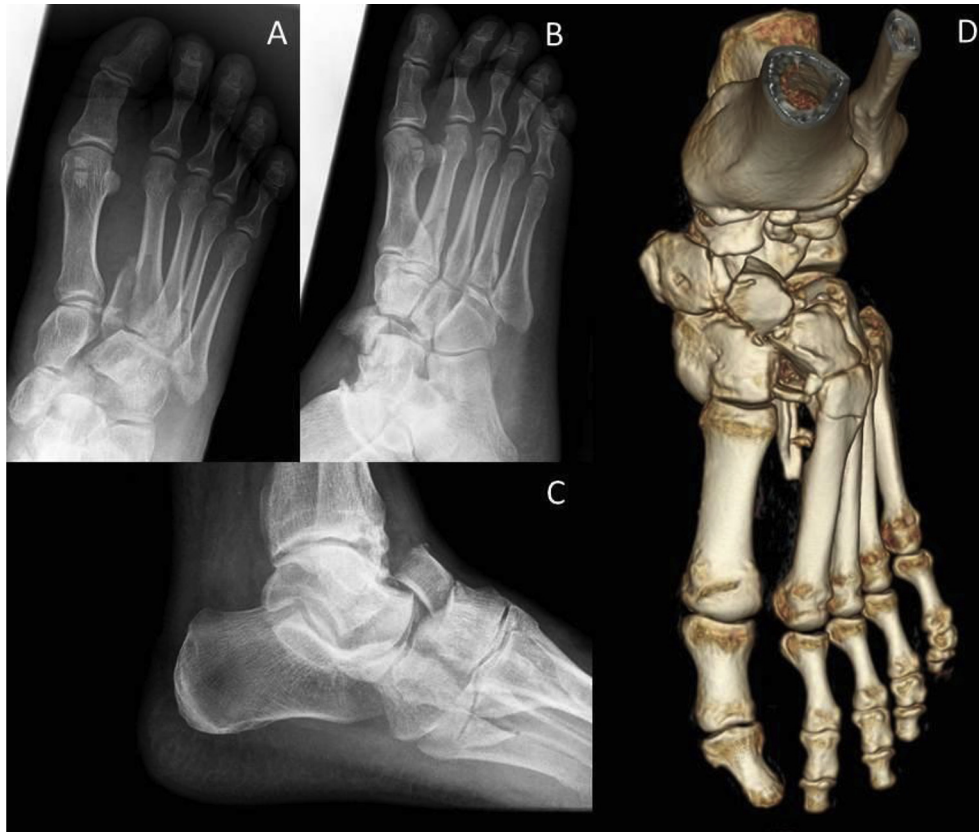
A Myerson type C2 injury of the tarsometatarsal joint. (A) Anteroposterior view. (B) Oblique view. (C) Lateral view. (D) Computed tomography with three-dimensional reconstruction.
